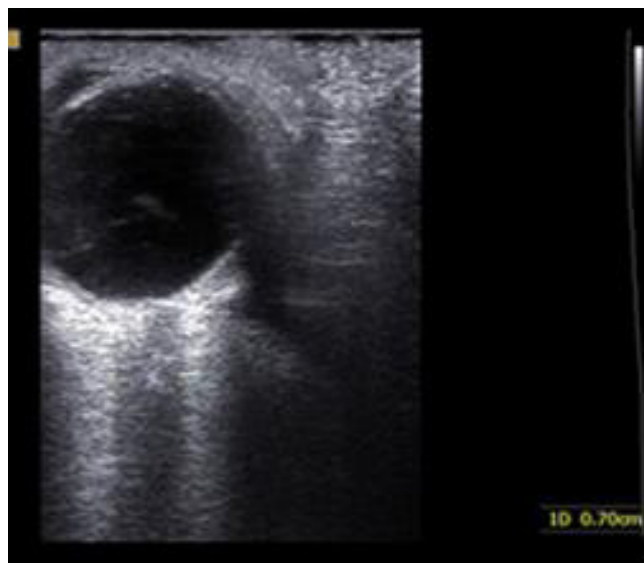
Dilation of the optic perineural space in male patient M. (main diagnosis — CML; ultrasound scan of the eyeball and orbital tissues with vascular dopplerography)
